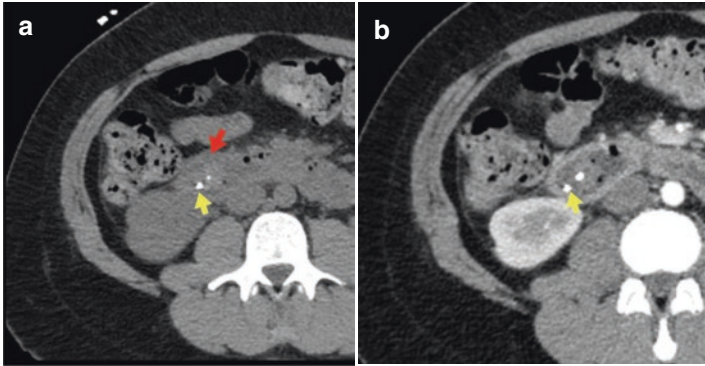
Computed tomography angiography (CTA). (a) Non-contrast image demonstrates slight hyperattenuation around the pancreatic stent terminating in the second portion of the duodenum, suspicious for blood clot. (b) Arterial contrast phase image demonstrates no change in attenuation, suggesting no active extravasation. Red arrow – region of hyperattenuation. Yellow arrow – pancreatic duct plastic stent
